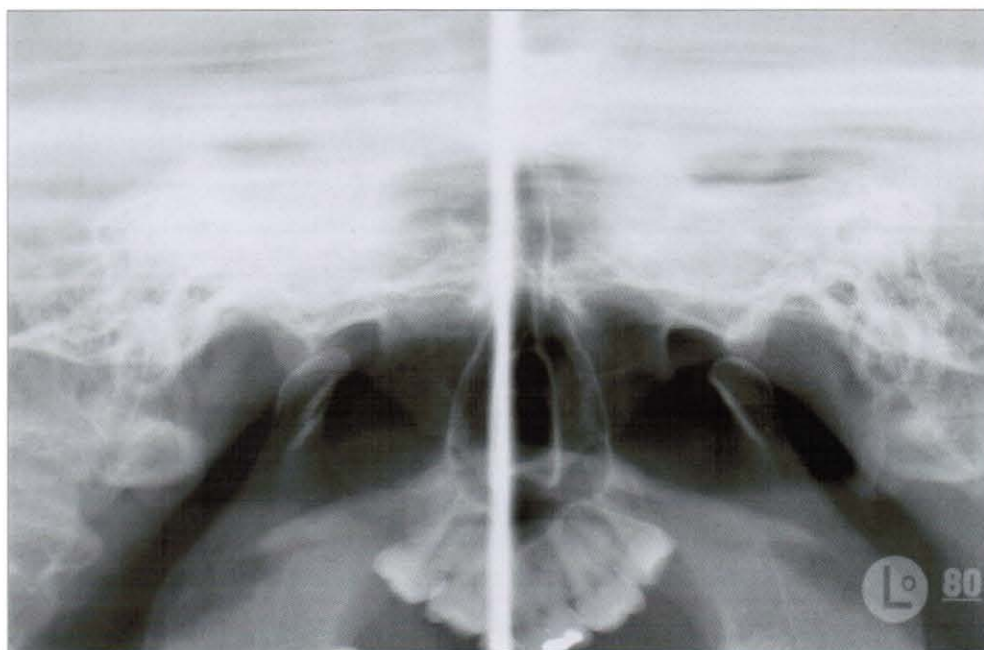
Pre-treatment TMJ panoramic radiograph
